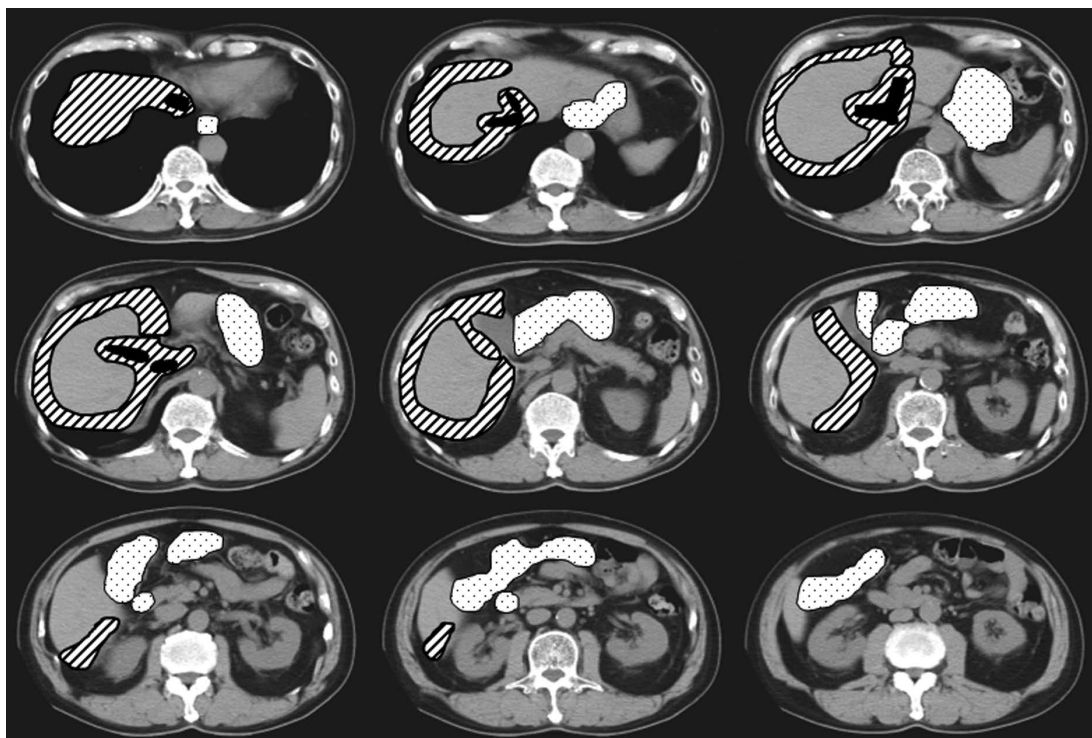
Computed tomography sections demonstrating typical locations treated with stereotactic body radiation therapy. Areas indicated with hatched lines can be safely treated with stereotactic body radiation therapy (SBRT), although these areas are difficult to approach for percutaneous ablation. Liver tumors located adjacent to the stomach and bowels (dotted areas) are not suitable for SBRT. Other unmarked areas can be treated either with SBRT or percutaneous ablation.
